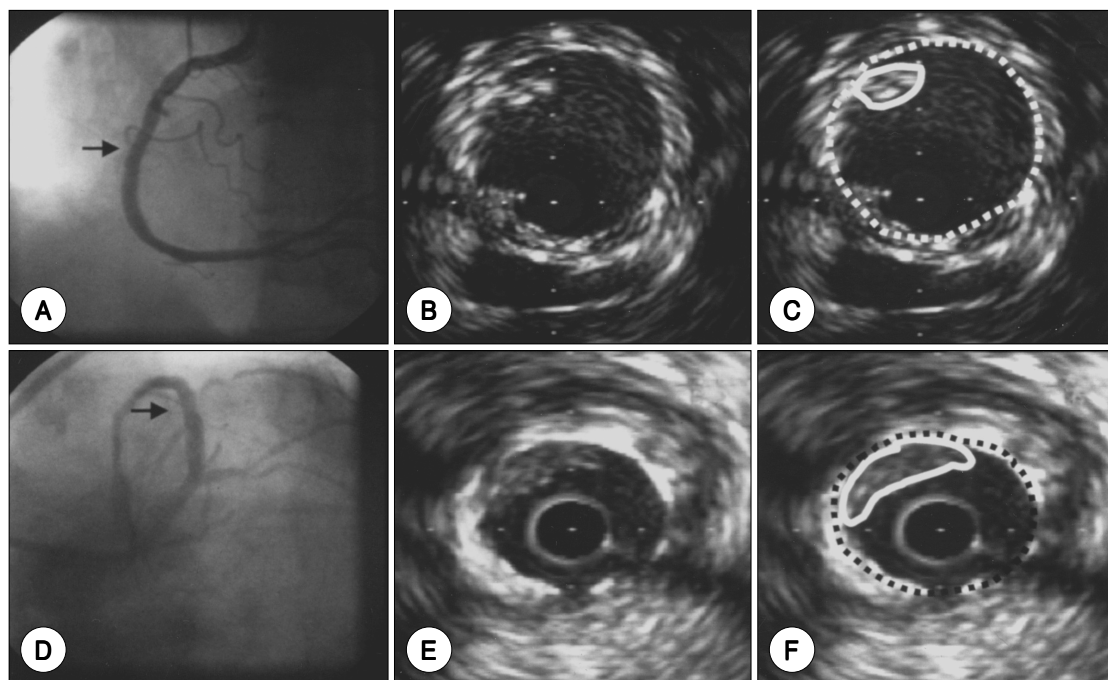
The coronary angiogram showed successful GFX stent implantation (arrow) at mid-portion of right coronary artery (A) and successful CrossFlex stent implantation (arrow) at proximal left anterior descending artery (D). Intravascular ultrasound images showed minor plaque (solid circle) within stent (dotted circle). B and C (GFX stent) are identical, and E and F (CrossFlex stent) are also identical.
